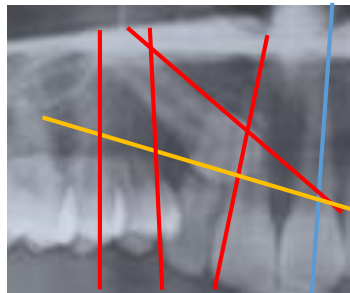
Close up panoramic radiograph of 1st quadrant. Poor prognostic of traction, according to the *Stivaros et al.* (2000) article ⁽⁶³⁾.
